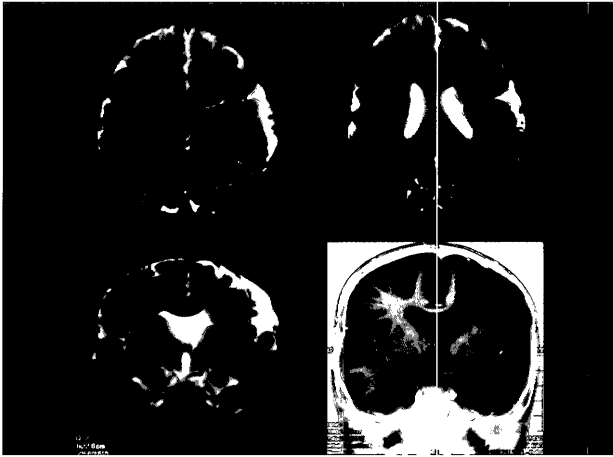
T2-weighted (spin echo TR = 3,500 msec TE = 100 msec) and inversion recovery magnetic resonance images of the lower right side.
